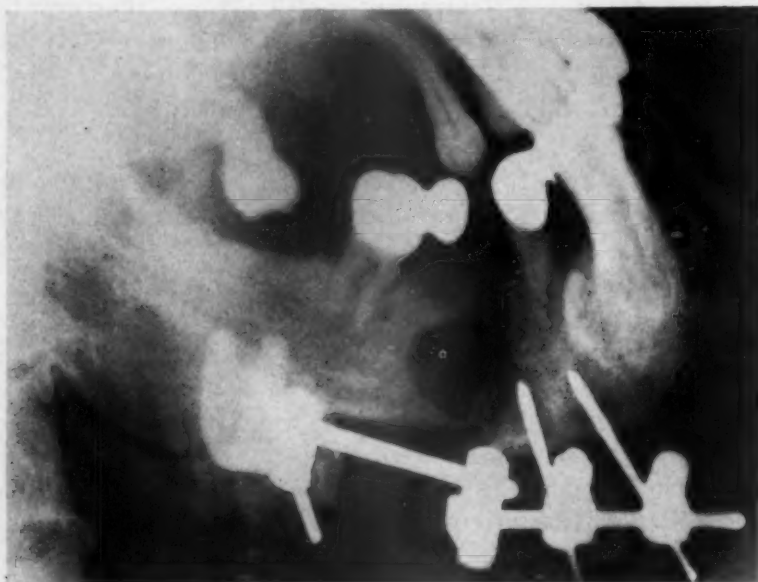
Postoperative x-ray showing immobilization with a peripheral bone clamp and pin fixation.
